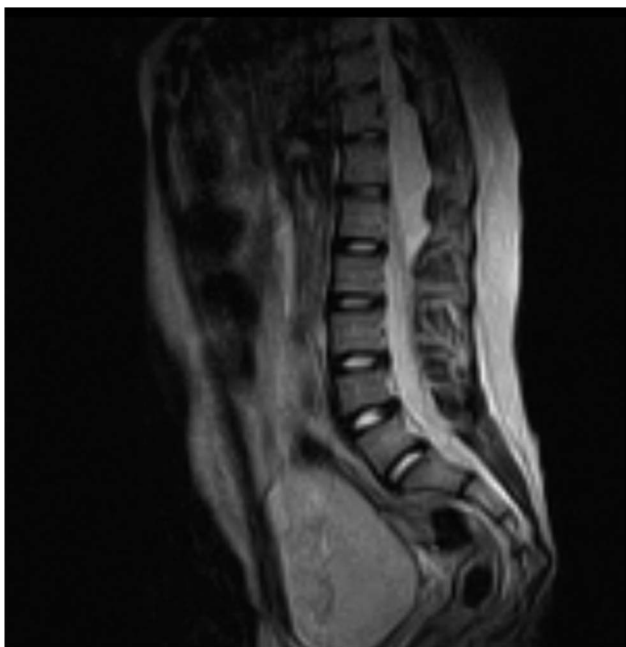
Sagittal MRI of the lumbar spine, revealing a compressive cystic lesion extending from T11 to L1.
